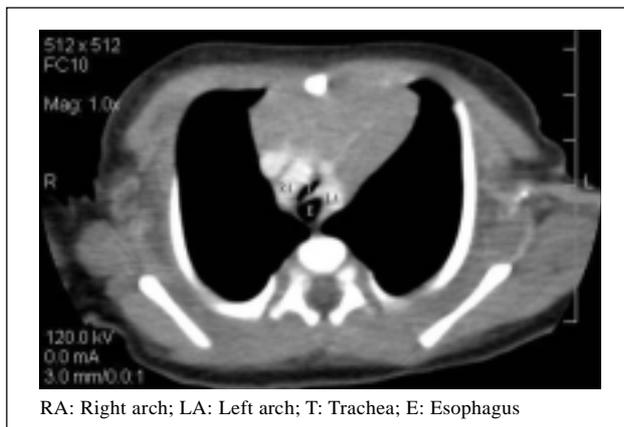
CT thorax showed double aortic arch causing focal tracheal narrowing.
